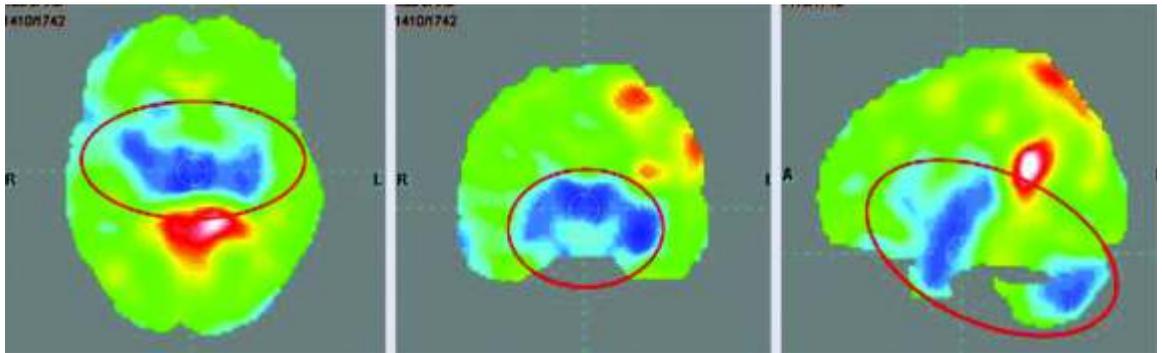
PET-CT scan before cellular transplantation showing reduced metabolism in the regions of hippocampus, basal ganglia and cerebellum bilaterally as indicated by the circles
